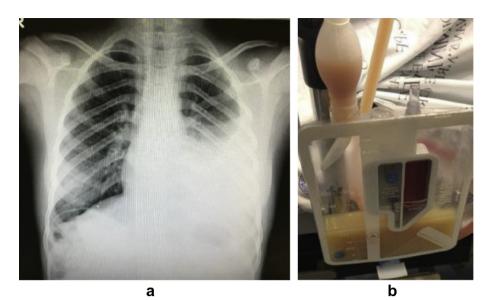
a: Chest radiograph on presentation shows left sided pleural effusion; 1b: Intercostal drain shows macroscopic appearance of chylous pleural fluid.
